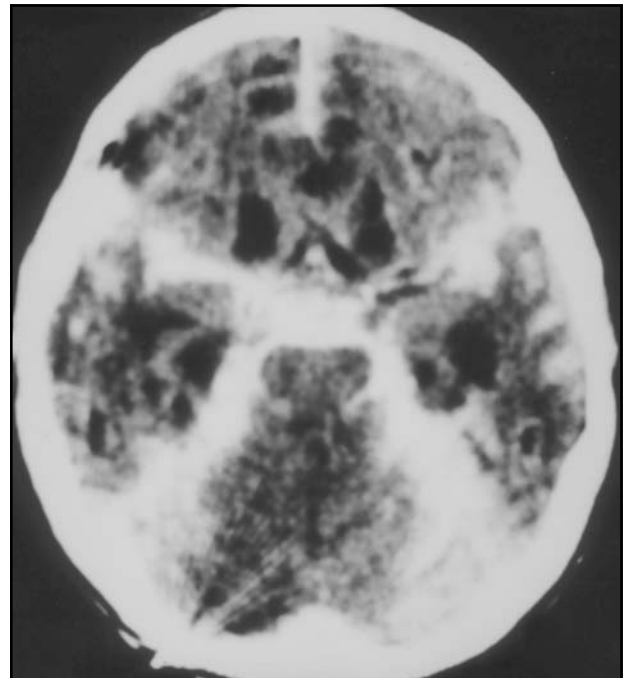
Contrast-enhanced CT scan shows a diffuse sub-arachnoid enhancement.
